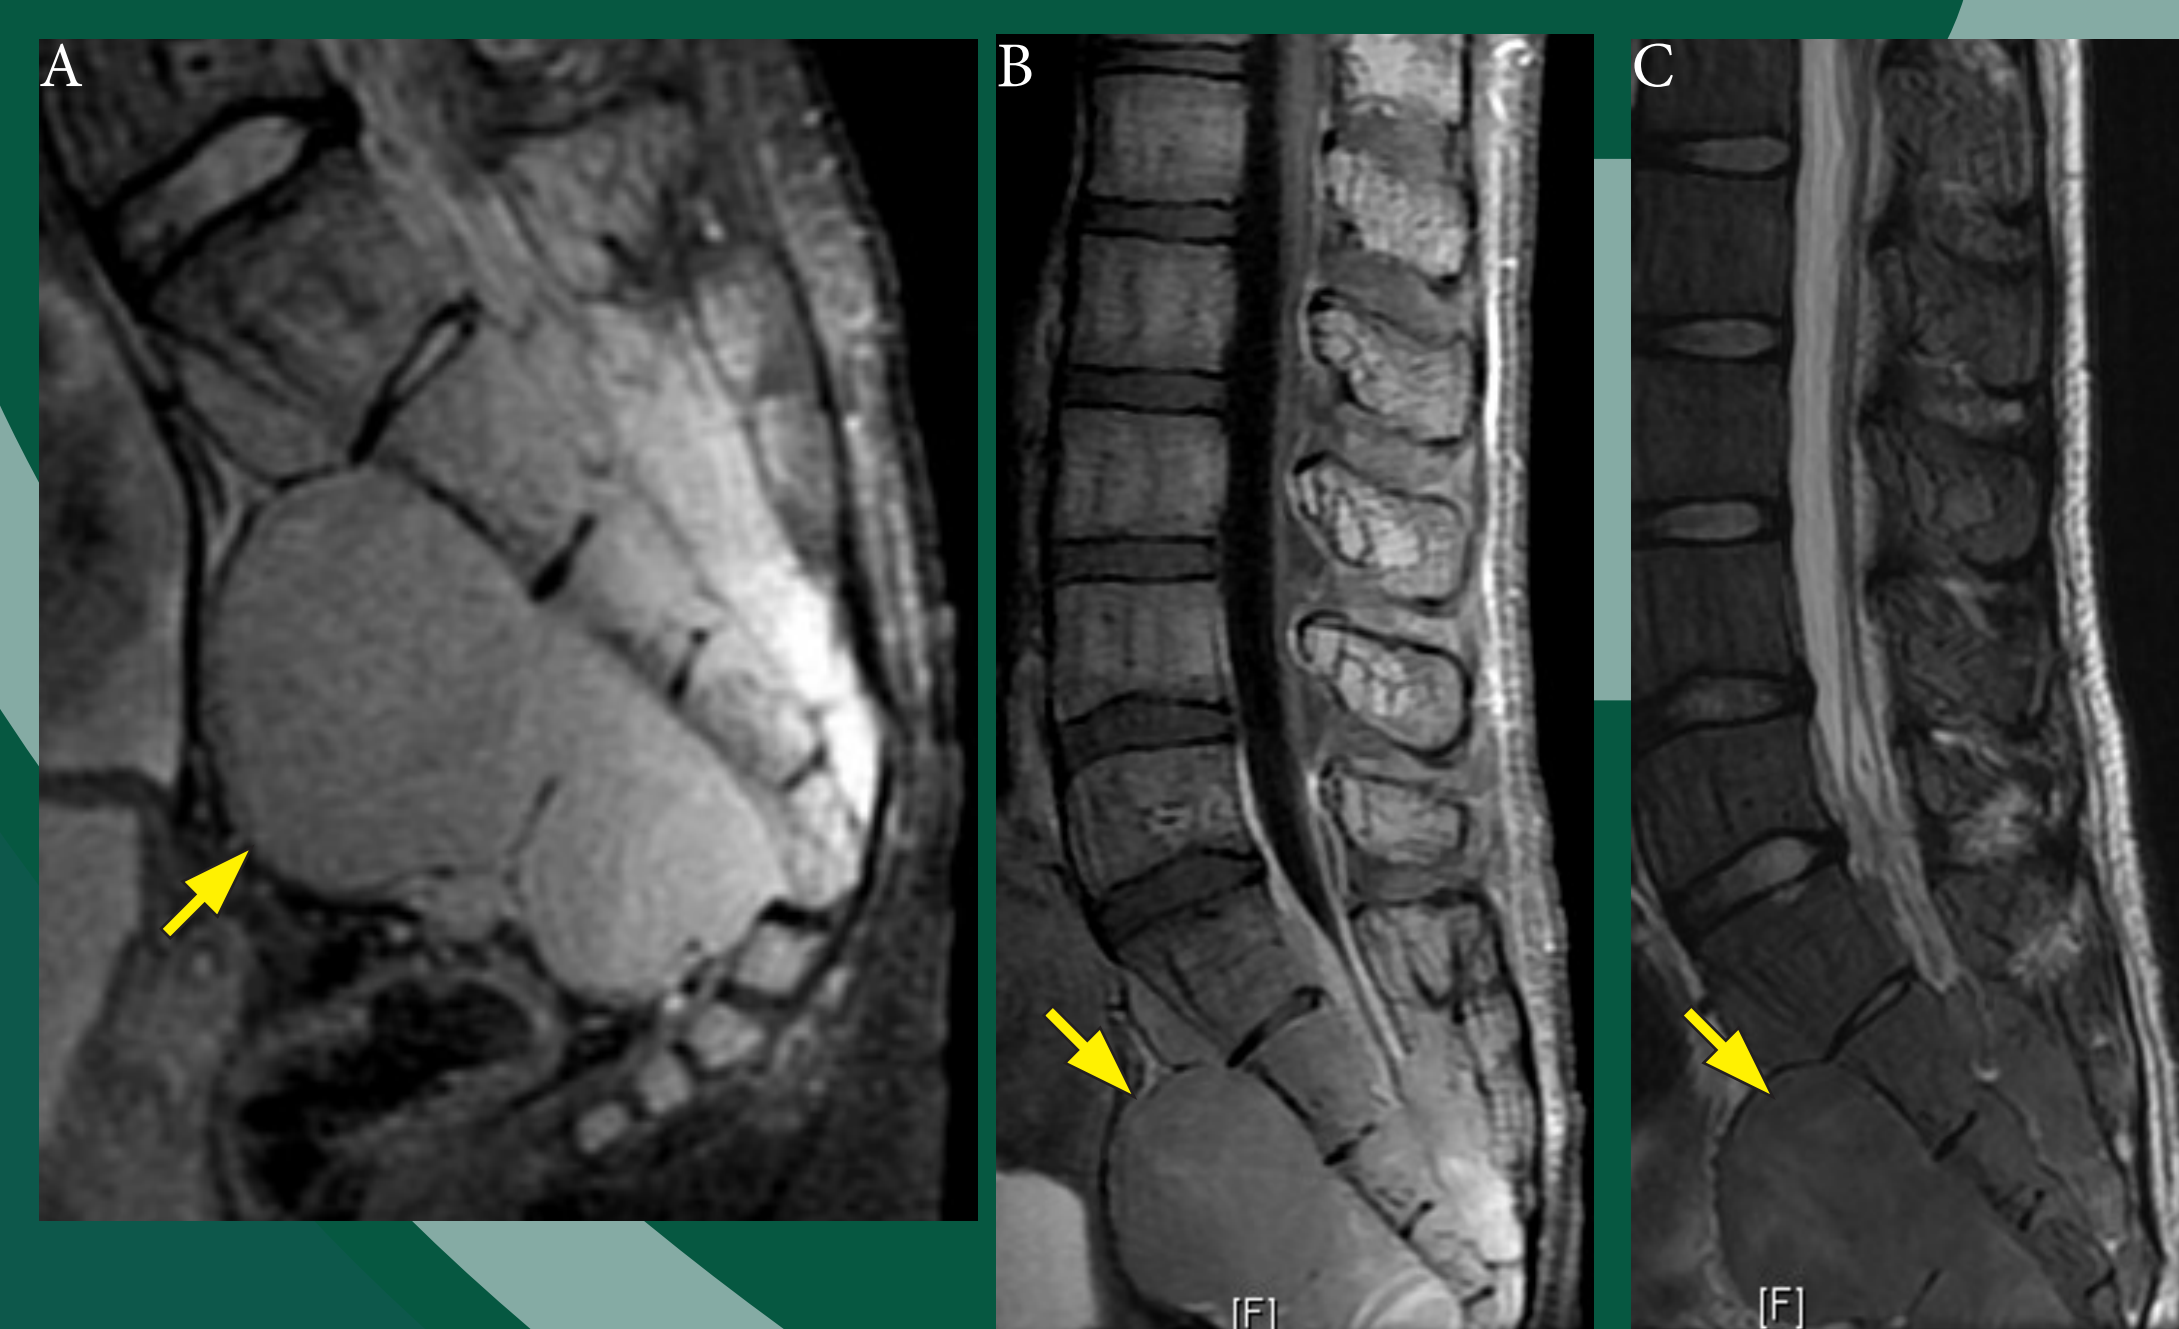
MRI of the lumbosacral spine. T1 (A-B) and T2 weighted (C) sagittal projections demonstrating a presacral mass with isointense T1 and T2 signal characteristics with enhancement on postcontrast images. Axial (D-E) projections revealing enlargement of the sacral foramen and soft tissue invasion into the sacral central canal consistent with EMH.
